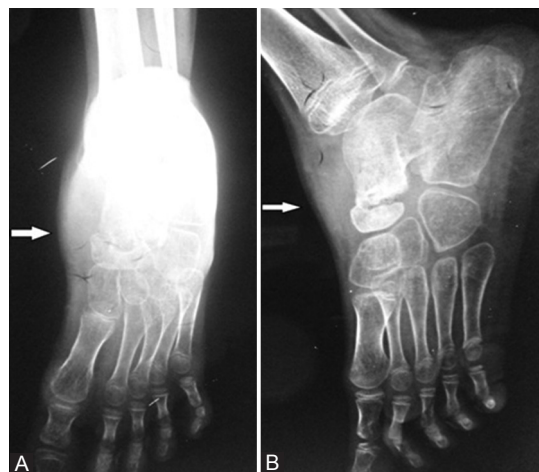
Pre-treatment radiographs of the foot (AP and oblique) showing diffuse osteopenia with narrowing of the talonavicular joint and erosion of the articular surface of talus and navicular and prominent soft tissue.
